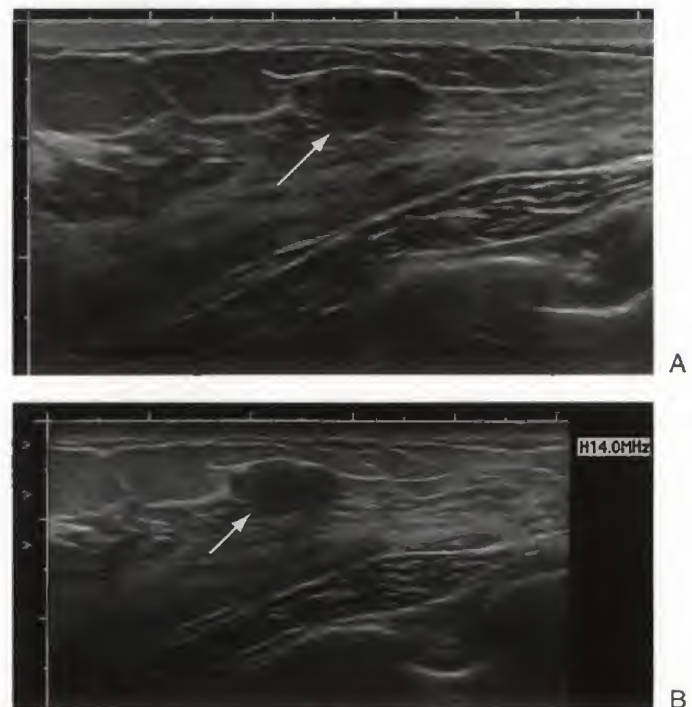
High contrast versus broad grayscale: invasive ductal carcinoma. *A.* This sonographic image is bright black and white which impairs ability to perceive echoes in the mass or its indistinct anterior margin. Strong enhancement and near-anechogenicity suggest erroneously that the mass is a simple cyst. *B.* Sonographic image of a mass in a different patient with the same diagnosis, poorly differentiated invasive ductal carcinoma, is easier to interpret. Its broad grayscale enables recognition of marginal detail and differences in the echogenicity of normal tissues and abnormalities. The cancer is just anterior to the pectoral muscle layer. US is unreliable in determining involvement; pectoral muscle enhancement on MRI is more reliable. Deep to the pectoral muscle, a portion of rib (*arrowhead*) can be seen.
